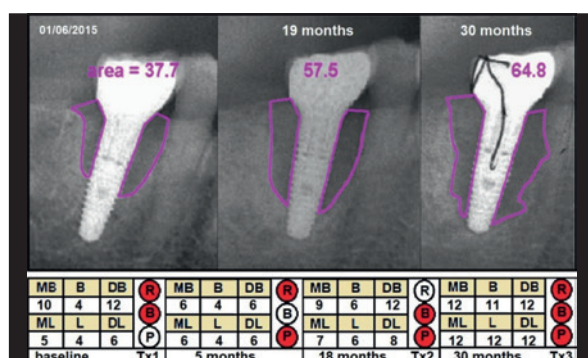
Example of a lost implant (Case 4), showing changes in radiographic defect (mm²), probing depth (PD; mm) and clinical signs from baseline to 30 months later. Violet = cross-sectional area; MB = mesiobuccal PD; B = buccal PD; DB = distobuccal PD; ML = mesiolingual PD; L = lingual PD; DL = distolingual PD; R = redness; B = bleeding; P = suppuration; Tx1 = first treatment; Tx2 = second treatment; Tx3 = third treatment.
